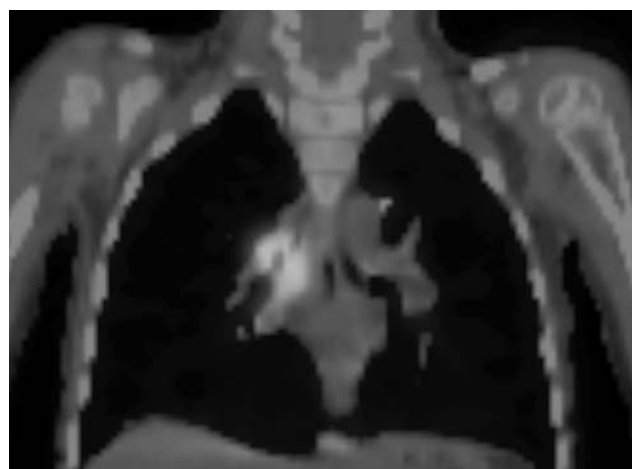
PET-CT shows the increases FDG uptake in the region of right main bronchus
